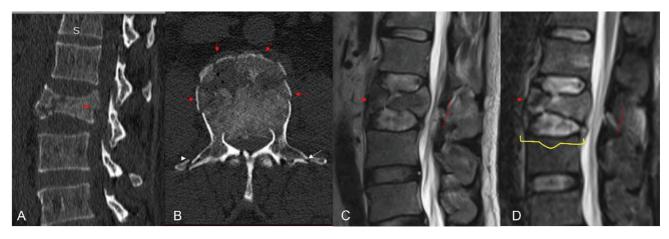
Computed tomography (CT) bone window sagittal reformatted (A) and axial (B) images display a complete burst fracture (red arrows) of the L2 vertebral body and bilateral transverse process fractures (white arrows). Sagittal magnetic resonance (MR) images—T2-weighted (T2W) (C) and short tau inversion recovery (STIR) (D)—reveal a complete burst fracture with definite ligament complex injury (red and yellow brackets) involving the ligamentum flavum, interspinous ligament, anterior longitudinal ligament, and posterior longitudinal ligament. Thoracolumbar Injury Classification System (TLICS): 6 points (surgical stabilization required). Arbeitsgemeinschaft für Osteosynthesefragen (AO Spine): L2 classified as A4-N0, indicating an unstable fracture with severe ligamentous injury that necessitates operative management to restore stability and prevent further complications.
